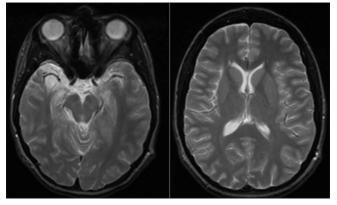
Preoperative axial T2WI MRI showing encephalomalacia involving the anterior and mesial aspect of the right temporal lobe, right frontal operculum, and right insula
